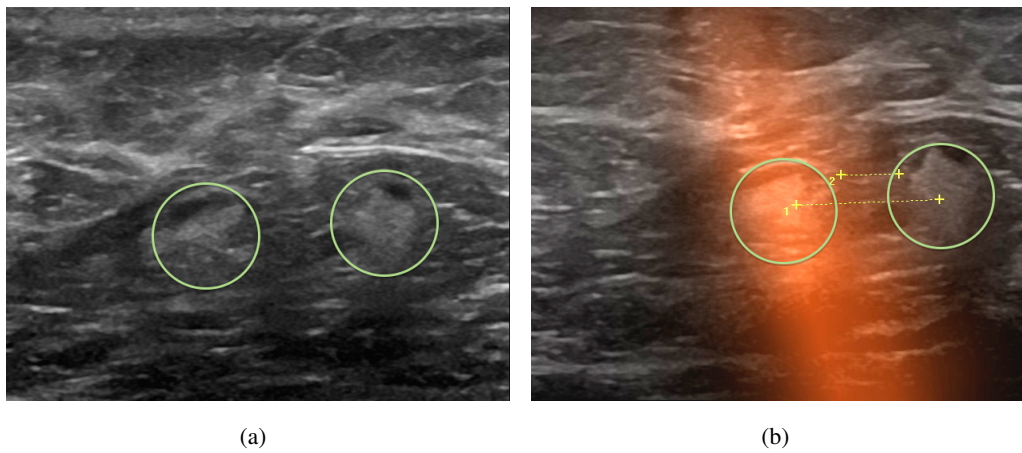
Freehand SPECT / ultrasound fusion for a patient inside the operating room. (a) Ultrasound image of two lymph nodes in the axilla. (b) Fused image of Freehand SPECT and ultrasound. Left lymph node is identified as the sentinel. The distance of the two lymph nodes is from centers 11.7 mm (1), from borders 4.7 mm (2).
